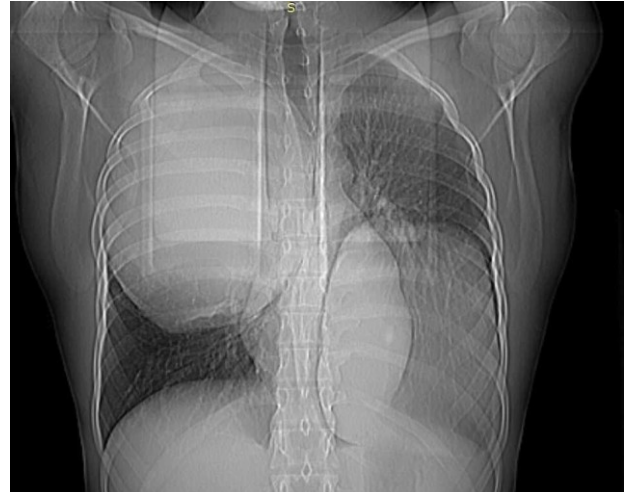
Plane chest X-ray (posteroanterior view) showing bilateral large homogenous well-defined opacity.
